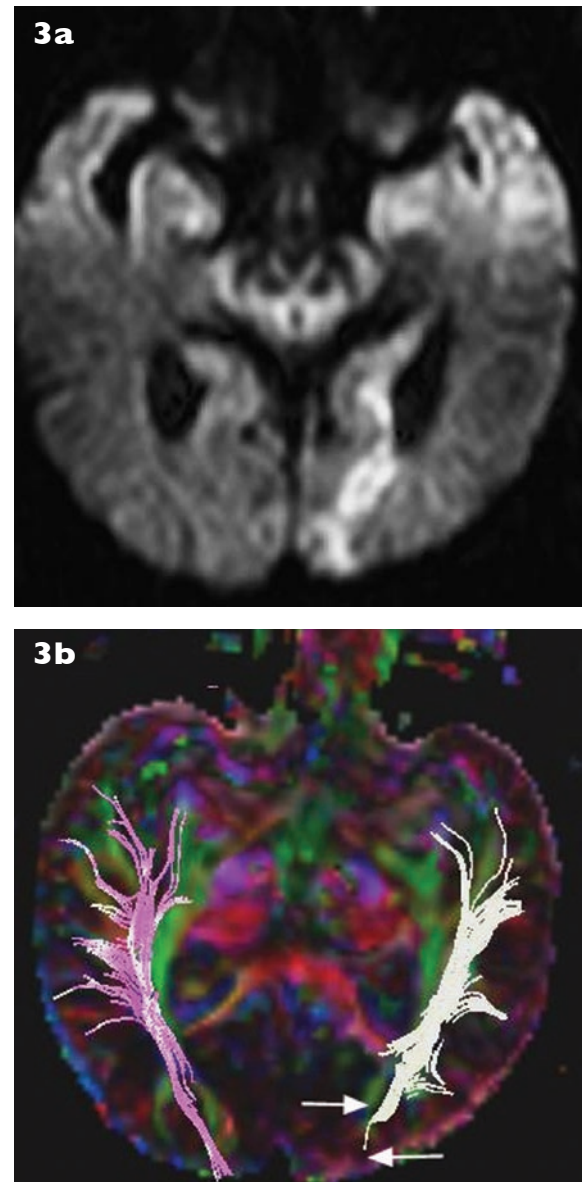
Case 3. (a) DWI shows acute infarction in the left occipital lobe with sparing of occipital pole cortex due to left posterior artery occlusion. (b) MR tractography shows disruption of terminal fibres of the left optic radiation (arrow).
